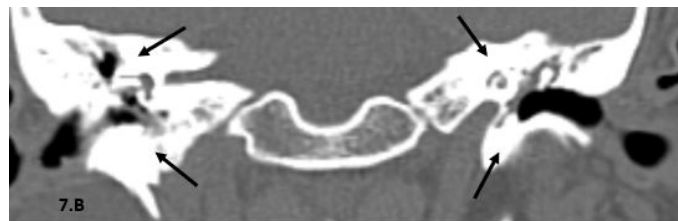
B: coronal CT view, bone window revealed bilaterally increased bone densities around inner and middle ear components (black arrows).
